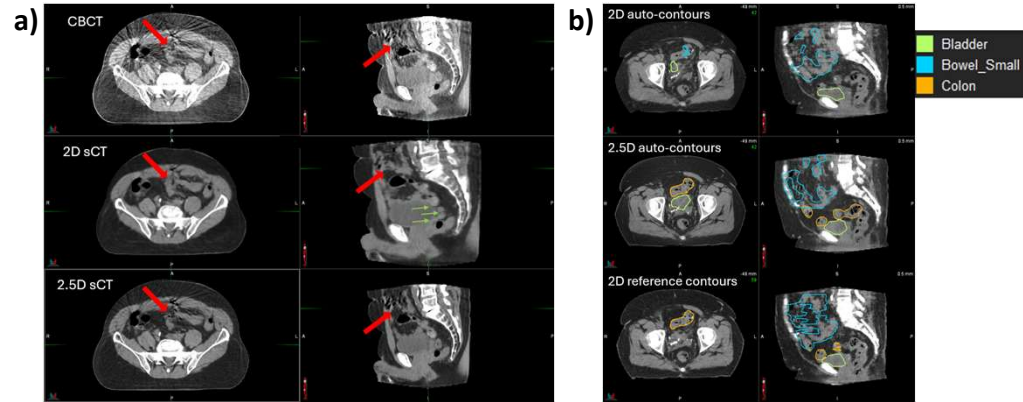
Axial and sagittal views of two example patients. (a) The 2D sCT model (middle row) hallucinated a one-slice loop of bowel (red arrows) and showed slice-by-slice inconsistencies in the bladder/rectum boundary (green arrows). The 2.5D model (bottom row) improved these slice-based anatomical inconsistencies to more accurately reflect the clinical CBCT (top row). (b) Auto-segmentation on the 2D sCT (top row) is hindered by slice-based inconsistencies that blur the bladder-colon boundary and obscure the small bowel. The 2.5D model (middle row) mitigates against these extreme segmentation failures by correcting these slice-based inconsistencies. V/L: 350/50 HU (CBCT), 400/40 HU (sCT)
